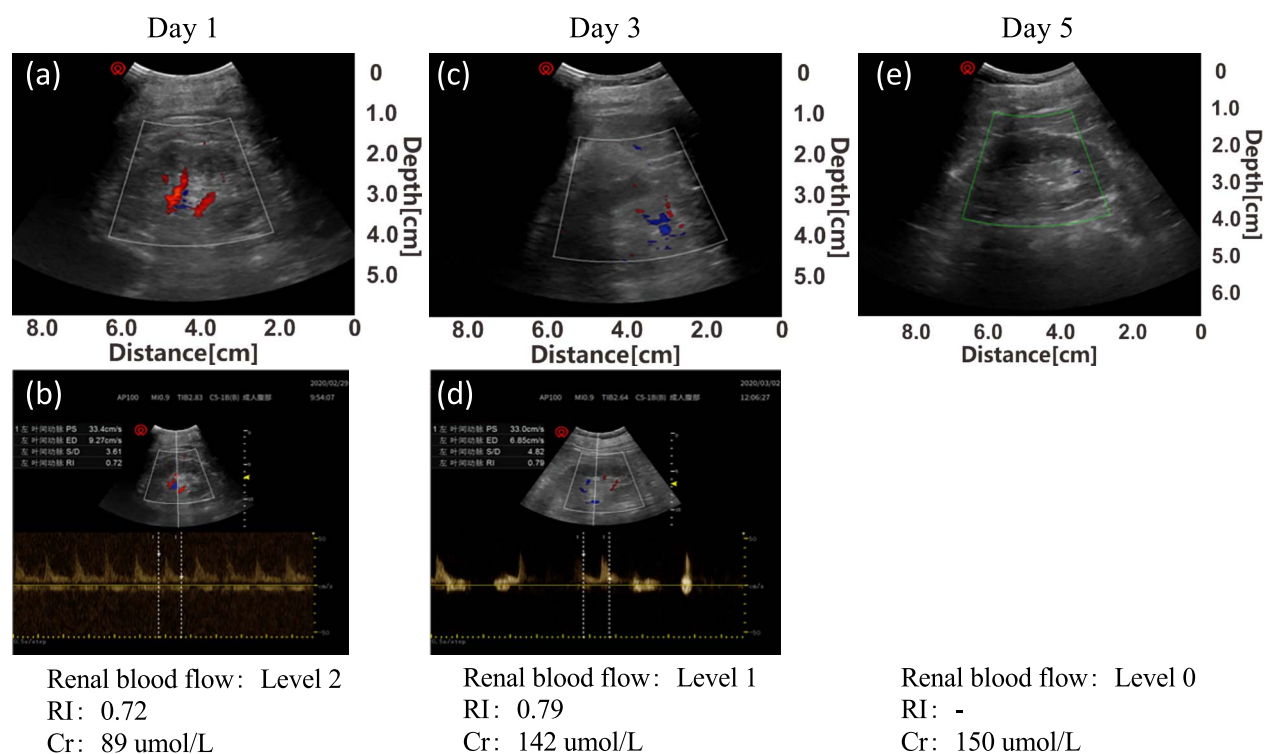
Renal function changes over time. The renal ultrasound assessment for pre-AKI and during AKI of a COVID-19 patient. (a) and (b) showed the renal blood flow and RI on day 1, (c) and (d) showed the renal blood flow and RI on day 2, and (e) showed the renal blood flow on day 3, because color Doppler cannot detect blood flow, and the RI cannot be calculated.
